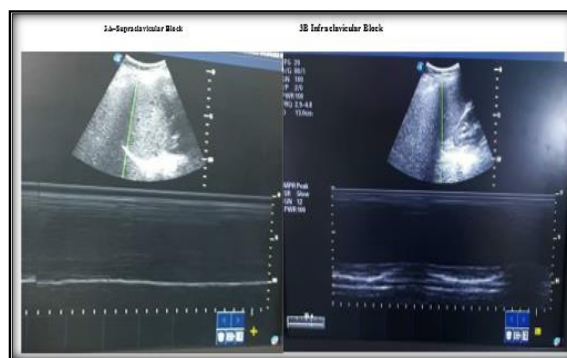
M mode Ultrasound of diaphragm
